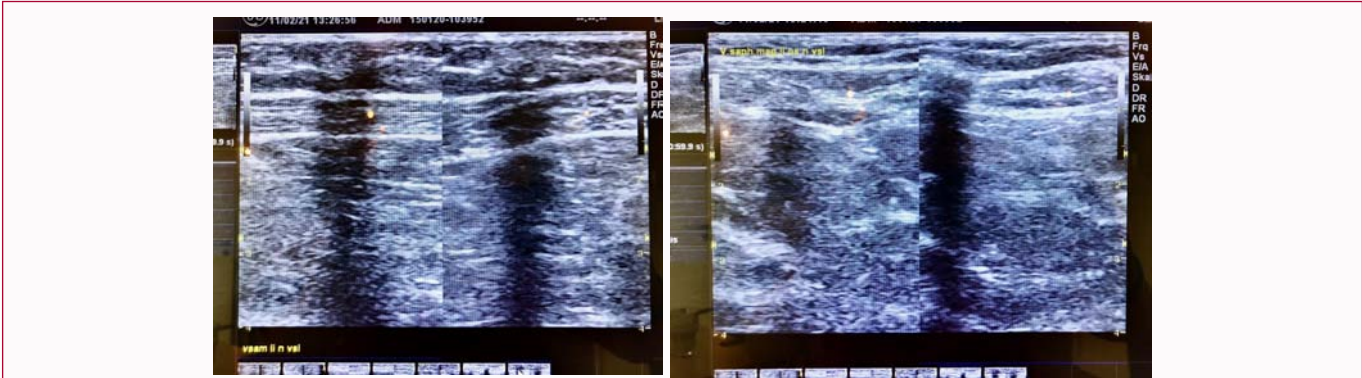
Post operative ultrasound - VenaSeal® closure of GSV and VSAM left leg.
